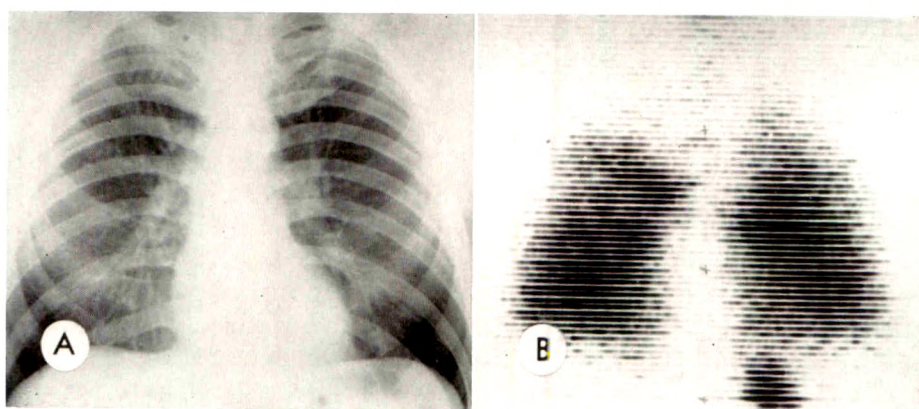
(A) Chest roentgenogram of a patient with scarring in the right upper lung field and at the base of the right upper lobe; bronchovascular thickening in left apex. (B) Ventilation scan of the same patient with decreased radioactivity in both apical regions, more extensive on the right, and in the lateral aspect of the upper half of the right lung.
